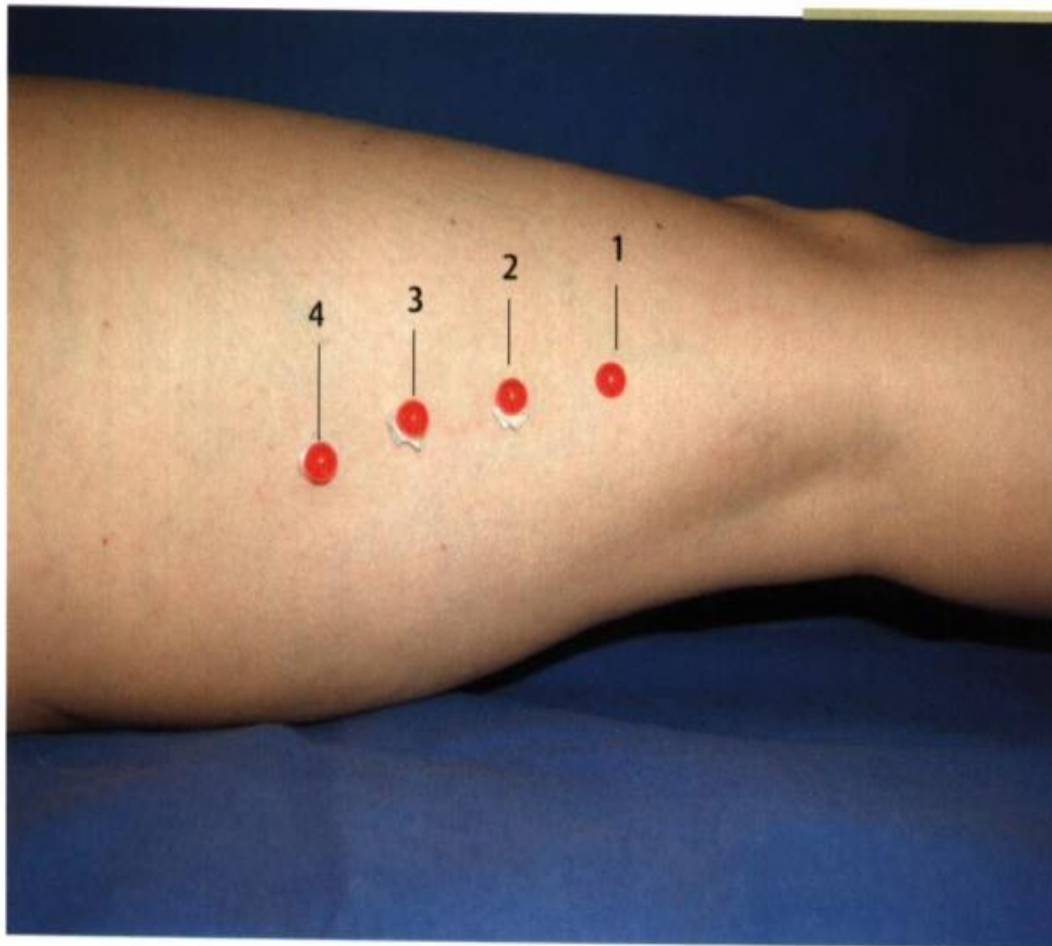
In general the lateral approach to the sciatic nerve can be used at any level, but the level of puncture has a considerable influence on the puncture angle in the dorsal direction. MRI investigations at three different levels proximal to the popliteal crease (12, 16, 20 cm) were used to determine the angle between the marked puncture site (between the vastus lateralis and the biceps femoris) and the sciatic nerve. As the gap between the vastus lateralis and the biceps femoris moves dorsally from distal to proximal, the angle of needle direction decreases as the distance from the popliteal crease increases.
